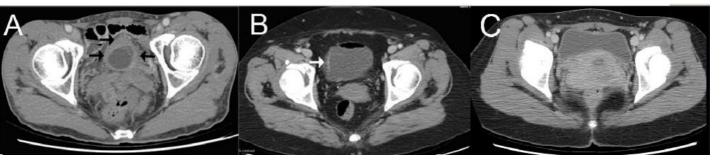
Bladder CT image in the patients with KC, ulcer type IC/BPS and non-ulcer IC/BPS. (A) Bladder CT in the patients with KC revealed diffuse bladder wall thickening (black arrow). (B) Bladder CT in the patients with ulcer type IC/BPS revealed right lateral wall focal thickening (white arrow). (C) Bladder CT in the patients with non-ulcer type IC/BPS revealed no specific finding.
